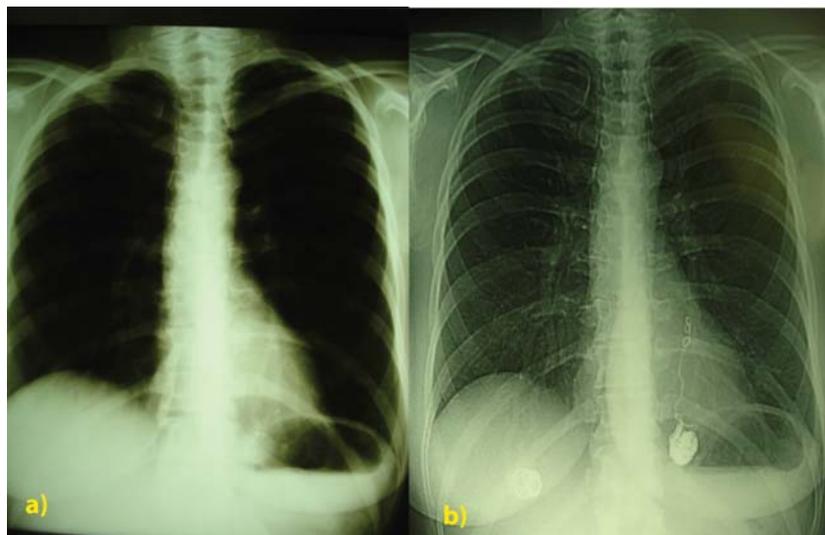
Chest x-ray findings: a) before, and b) after embolization.
